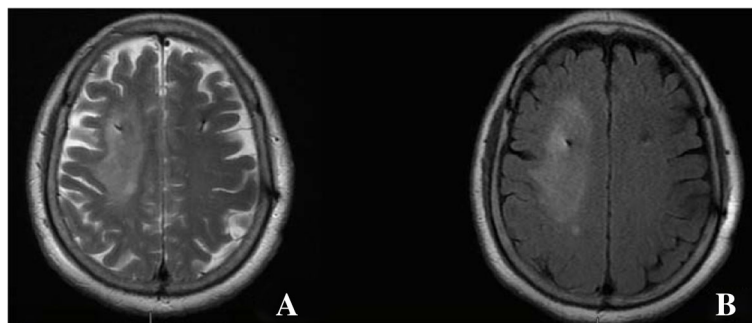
Post-operative MRI images for Case 12 showing cerebral infarction under the burr hole around the right DBS lead. a T2-weighted imaging. b Fluid-attenuated inversion recovery imaging
